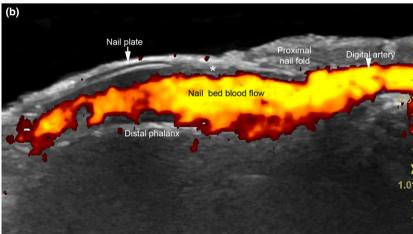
(a) 3D power angio reconstruction demonstrates increased thickness and blood flow in the nail bed of the right thumb. Notice the upward displacement of the nail plate. (b) Power Doppler ultrasound image of the right ring finger demonstrates prominent hypervascularity within the nail bed and a dilated digital artery. There is upward displacement of the nail plate and loss of definition (*) of the proximal part of the ventral plate.
